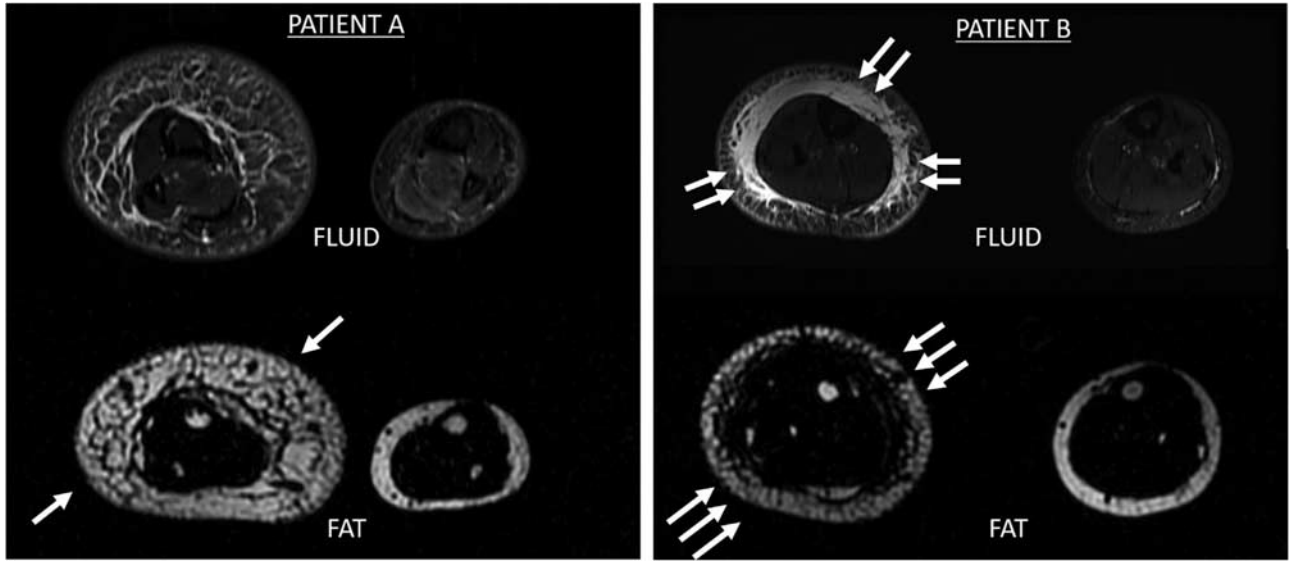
Examples of fat-dominant versus fluid-dominant soft tissue swelling in lower extremity lymphedema demonstrated on MRI. T2-weighted STIR (short-T1 inversion recovery) images (top row) and fat-specific Dixon images (bottom row) are shown across the mid-calf of two different patients with unilateral right lower extremity lymphedema. A, In Patient A's imaging, severe circumferential subcutaneous fat hypertrophy throughout the right calf is the primary contributor to asymmetric enlargement of the limb, as demonstrated by a relatively greater amount of high signal intensity on the fat-specific image (single arrows). B, In Patient B's imaging, on the other hand, the bulk of the relative enlargement of the calf is due primarily to extensive subcutaneous edema (double arrows). Fat hypertrophy is also present in the left calf, but only to a mild degree (triple arrows). MRI indicates magnetic resonance imaging.
